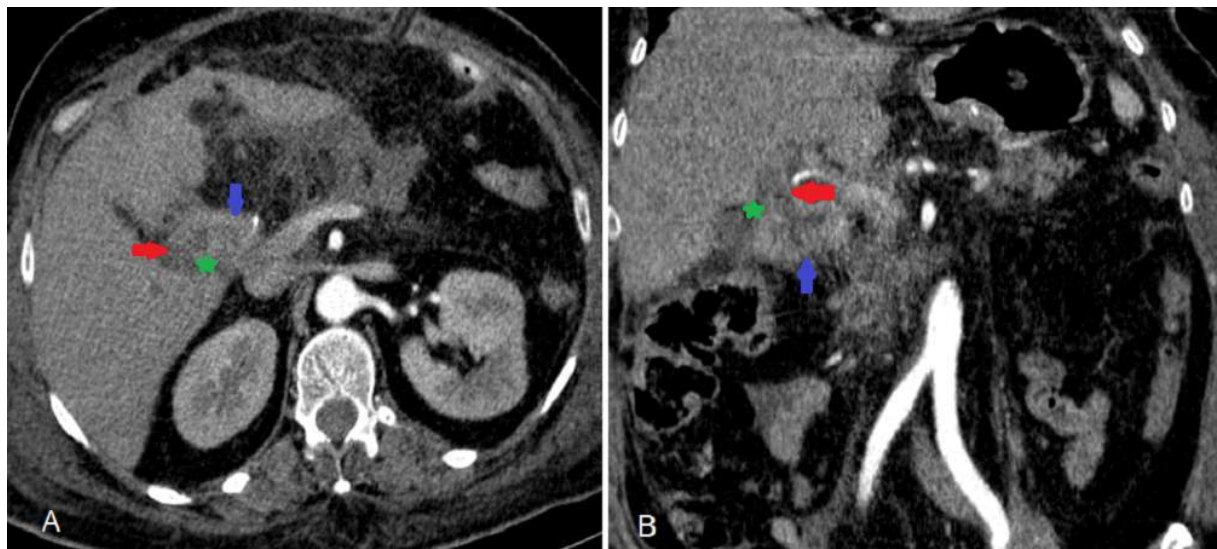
Abdominal and pelvic CT injected at an arterial phase in axial (A) and coronal (B) sections showing the biliary digestive anastomosis (green star) between the jejunum (blue arrow) and the residual bile duct (red arrow)
